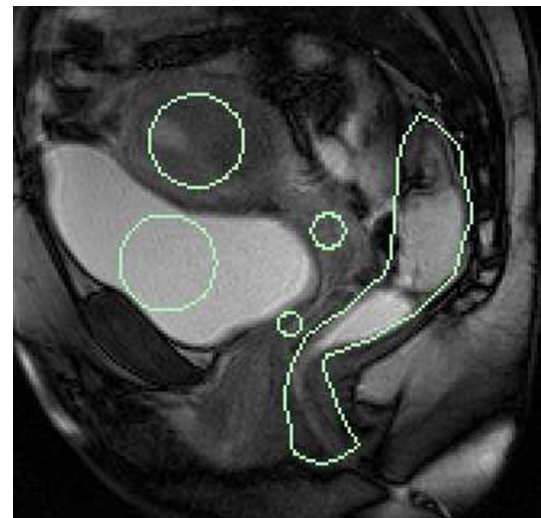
Uterus and bladder segmentation in sagittal midline MRI. e_M (circles on the left) and f_M (right)
